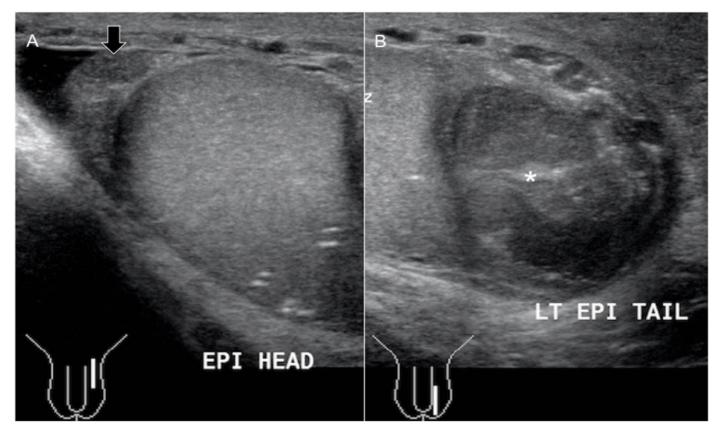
Ultrasound images (A & B) of the left scrotum. The sagittal view of the left scrotum shows a well-defined heterogeneous hypoechoic lesion (*) arising from the tail of the left epididymis. Note is made of the normal appearance of the head of the left epididymis (black arrow)
